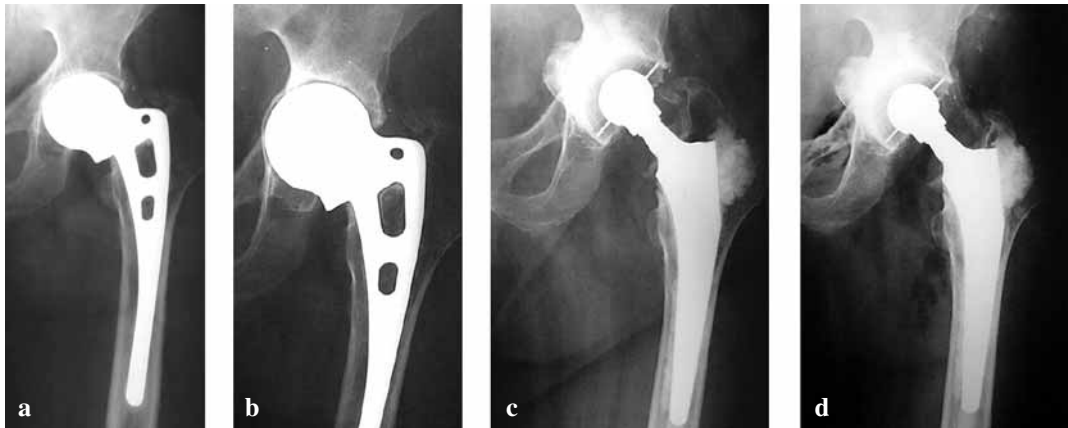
(a) Postoperative radiograph with good acetabular floor.
